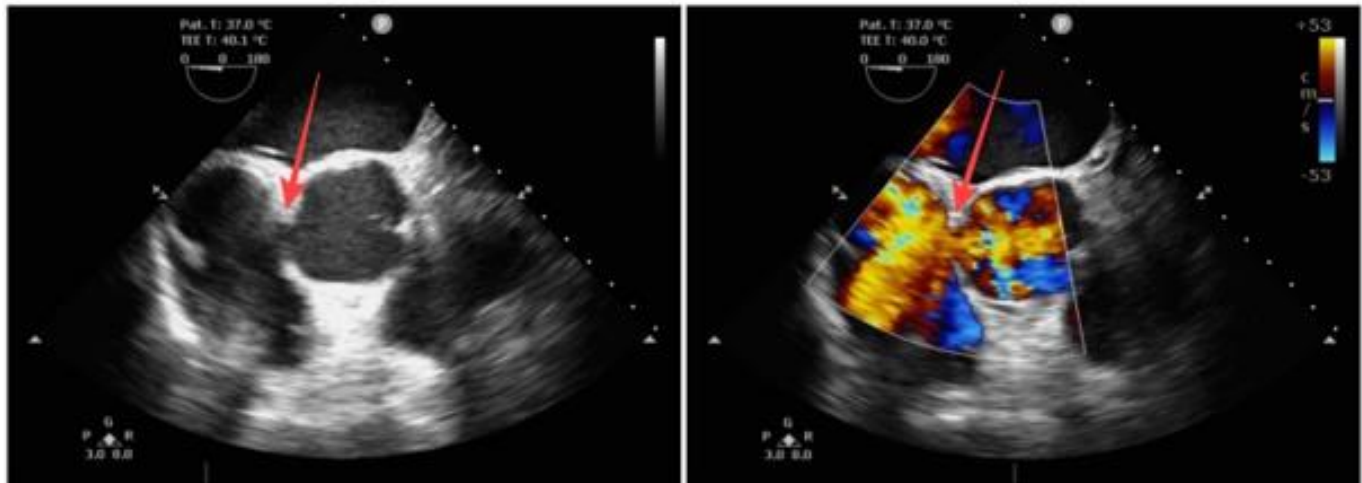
Echocardiographic image before surgery. The arrow indicates the site of the aneurysm rupture into the right atrium.
